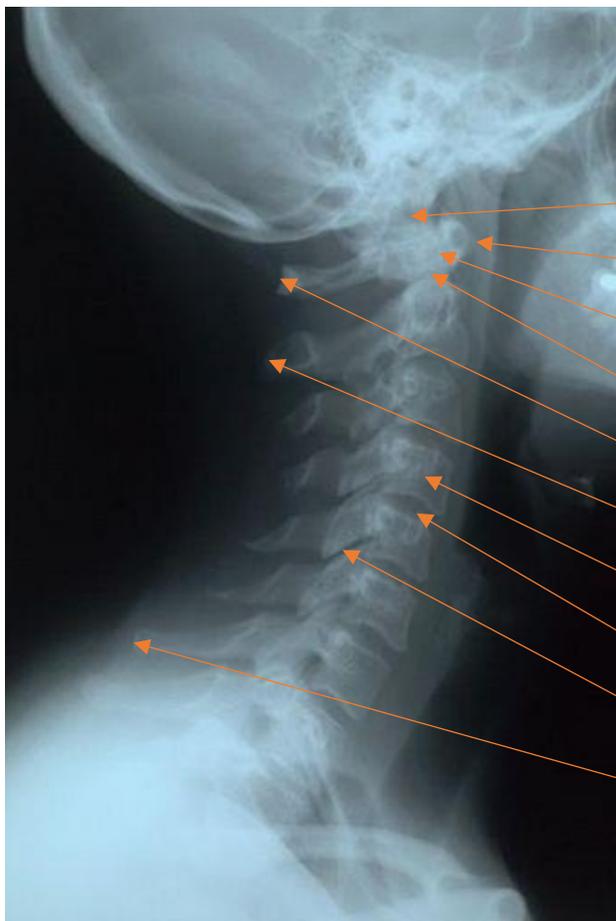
Cervical spine X-ray from side
